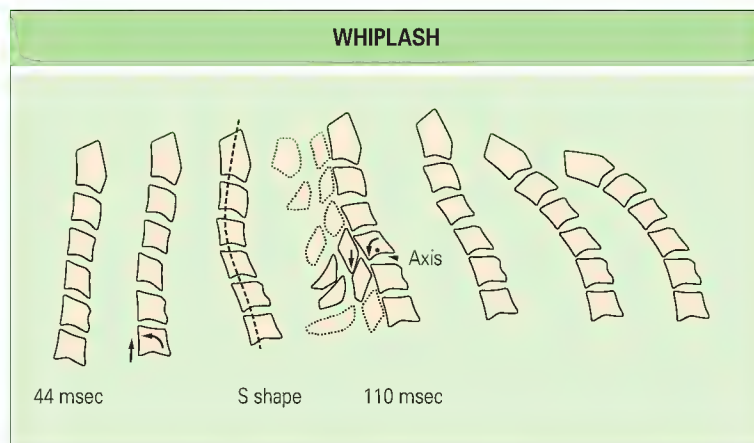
Appearance of sequential radiographs of the cervical spine during the extension phase of whiplash. At 110 msec the C5 vertebra rotates about an abnormally high axis of rotation, which causes the vertebral body to separate anteriorly from C6 and the inferior articular process of C5 to chisel into the superior articular process of C6. (Modified from Barnsley L, Lord SM, Bogduk N, Teasell RW, Shapiro A. *The pathophysiology of whiplash*. In: Malanga, editor. *Cervical flexion-extension/whiplash injuries*. Spine: state of the art reviews. Philadelphia: Hanley & Belfus; 1998, p. 209-42; and Kaneoka K, Ono K, Inami S, Yokoi N, Hayashi K, editors. *Human cervical spine kinematics during whiplash loading*. International Conference on New Frontiers in Biomechanical Engineering. Tokyo: 1997.)
